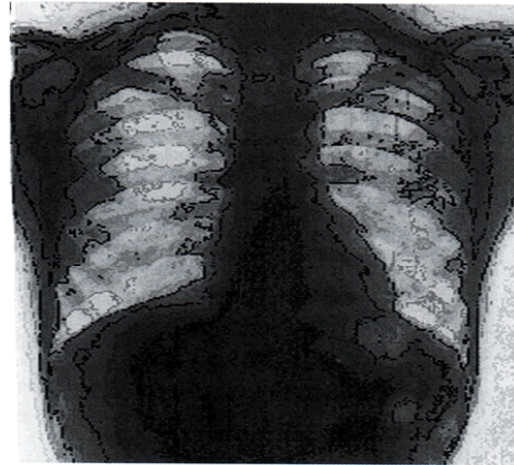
Chest X-Ray showing tracheostomy tube lying in right main bronchus.
